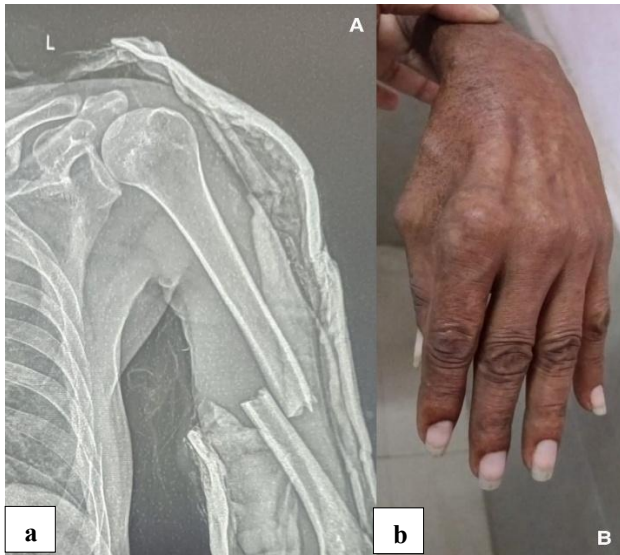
Preoperative imaging and clinical presentation of radial nerve palsy, (a) radiograph of the left arm showing a displaced mid-shaft fracture of the humerus, the fracture has been temporarily stabilized using a U-slab for initial immobilization; and (b) clinical photograph demonstrating partial wrist drop and finger drop at the metacarpophalangeal joints - inability to extend the wrist and fingers- indicative of high radial nerve palsy distal to the triceps innervation, elbow extension remains preserved, consistent with the nerve injury occurring at or distal to the spiral groove.
